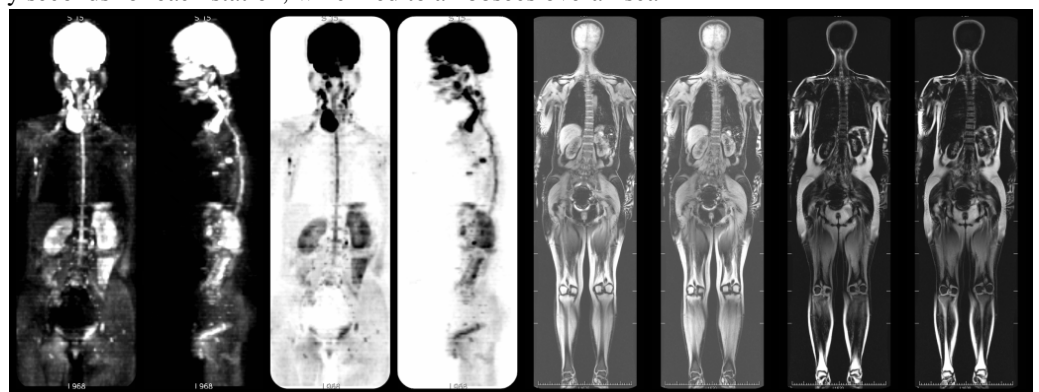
Whole body DWI and lava-flex of a 59 year old female volunteer, who was found to have thyroid nodules and spleen deficiency.
